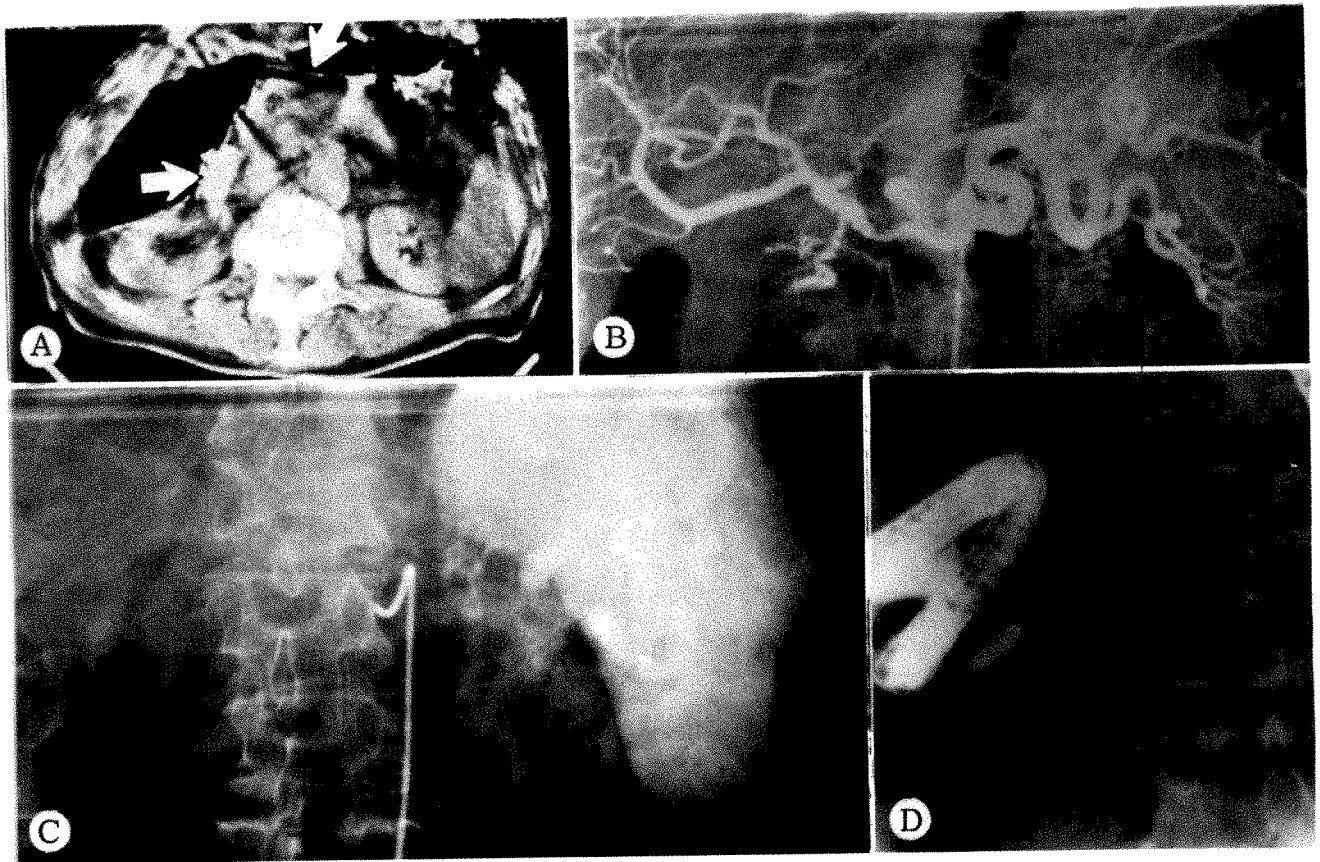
75-year-old man with weight loss and epigastric pain had evidence of esophageal varices and hypersplenism. A, CT scan showing large, diffuse, ill-defined mass obscuring tissue planes located in region of head of pancreas, medial to second portion of duodenum (*arrow*) and posterior to antrum of stomach (*arrow*). B, Celiac angiogram, arterial phase, showing evidence of carcinoma of pancreas involving origin of celiac axis, proximal portion of hepatic artery, and gastroduodenal artery. C, Celiac angiogram, venous phase, showing obstructed splenic vein. Epiploic veins are enlarged, serving as collateral channels of venous drainage, and spleen is enlarged. D, Endoscopic retrograde cholangiopancreatogram. Main pancreatic duct obstructed. Unresectable carcinoma of pancreas found at operation.
